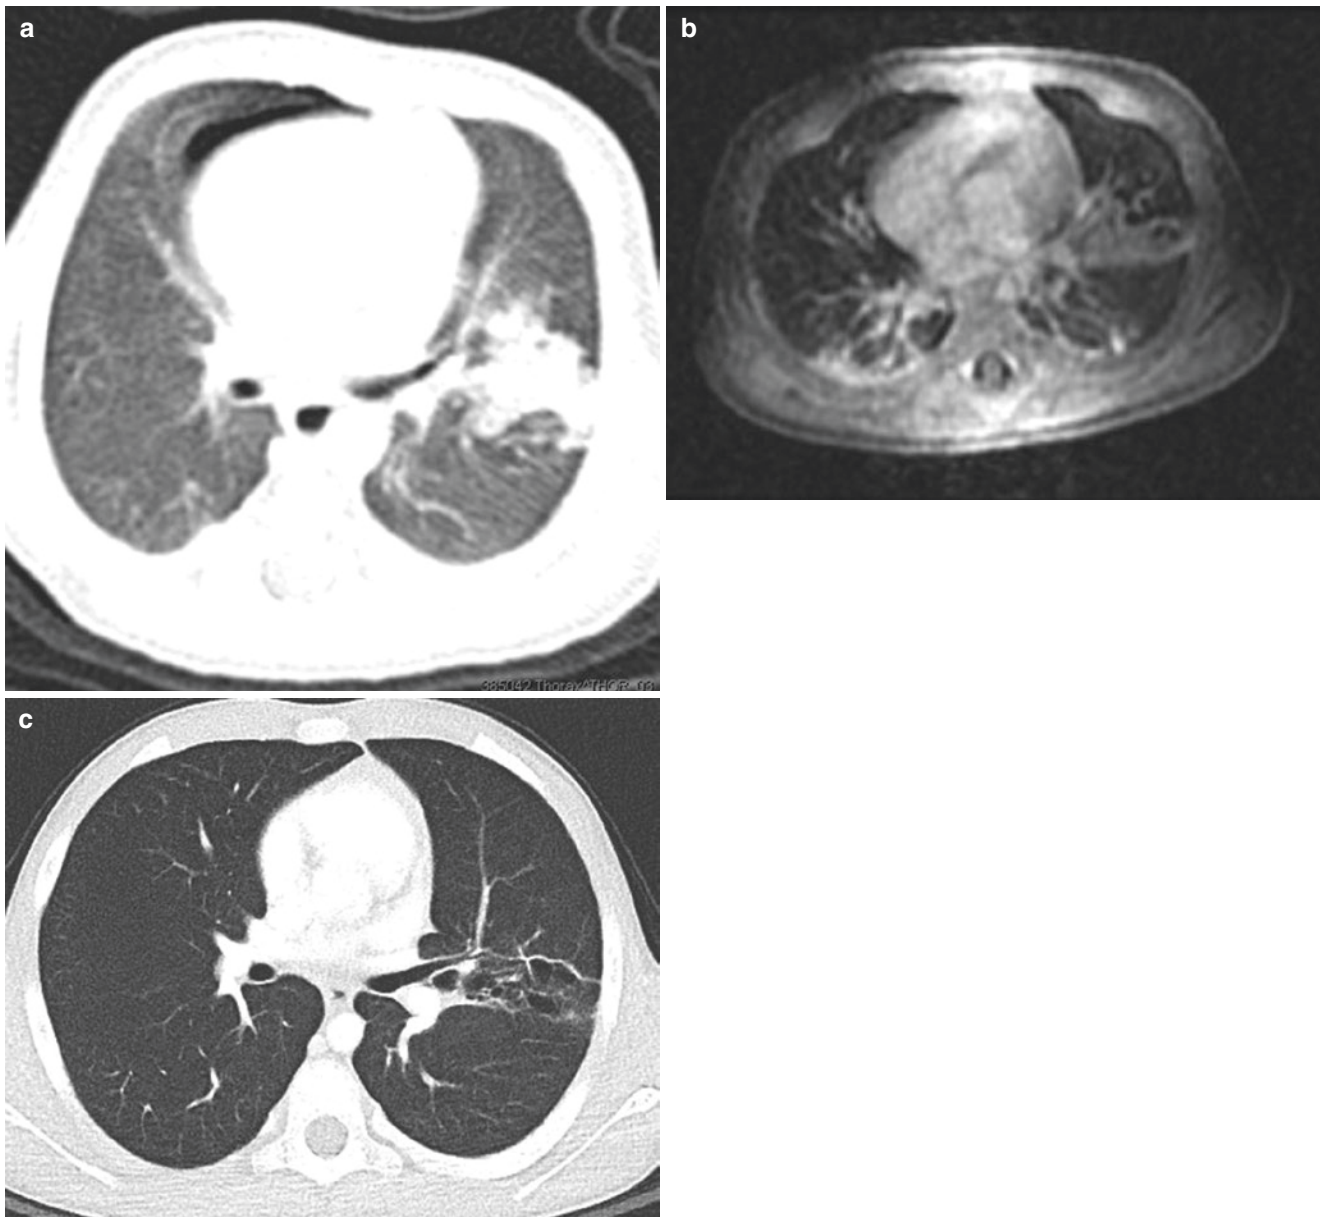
A 3-year-old girl with congenital pulmonary airway malformation (CPAM) imaged at three different time points. (a) Axial non-enhanced lung window CT image obtained at day 1 of life shows consolidation within the left lower lobe. Small right pneumothorax is incidentally noted. (b) Axial contrast-enhanced SPGR MR image
